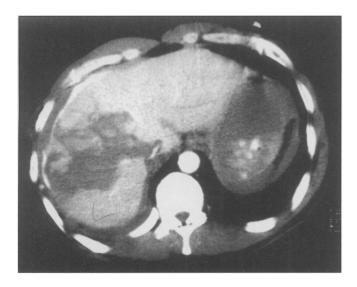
CT scan demonstrating a deep parenchymal laceration between segments V and VIII anteriorly (anterior sector) and segments VI and VII posteriorly (posterior sector).
